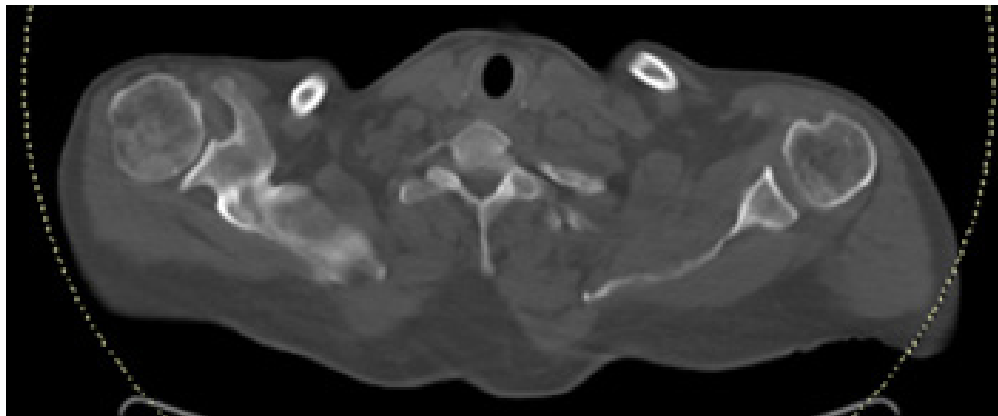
Same axial PET/CT image as in fig. 1, indicating increased uptake of 18F-FDG in both humeral heads. Increased uptake is remarked at the upper border of the right scapular bone and the first thoracic vertebra.
